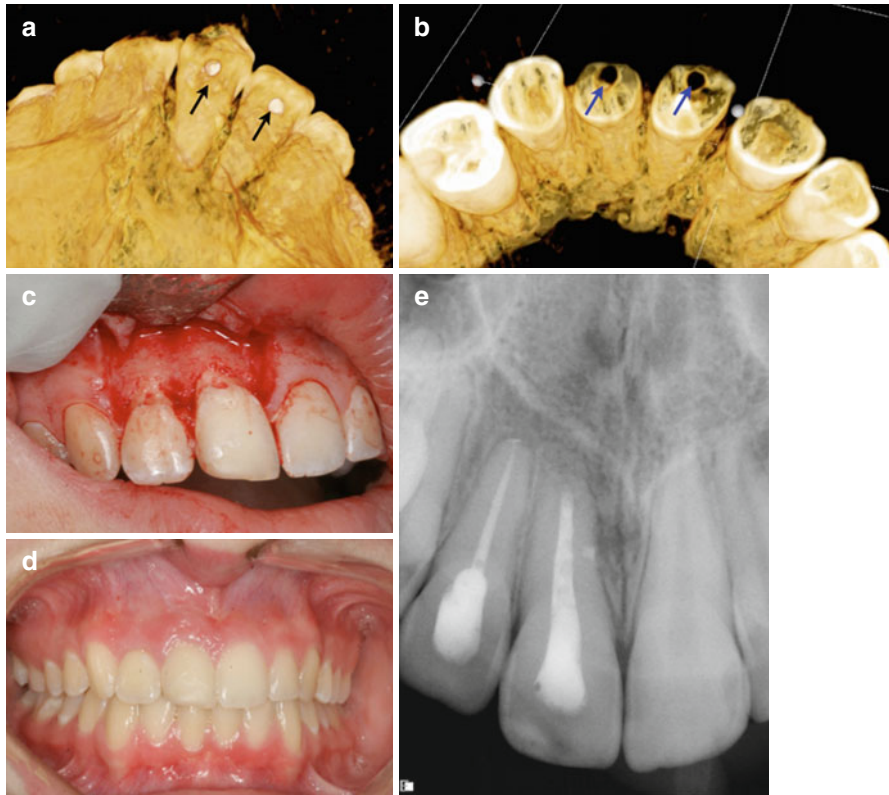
Continuation of case in Fig. 3.9. (a, b) are 3D reconstructions showing the facial perforations (*black and blue arrows*) on teeth #7 and 8. (c) Reflection of a full-thickness mucoperiosteal flap confirmed the presence of perforations on both teeth. The perforations were repaired with Geristore™ (DenMat, Lompoc, CA). Both teeth were then treated via an orthograde approach with subsequent surgical root-end resection and filling of tooth #8. (d, e) One-year recall radiograph demonstrating soft and hard tissue healing
